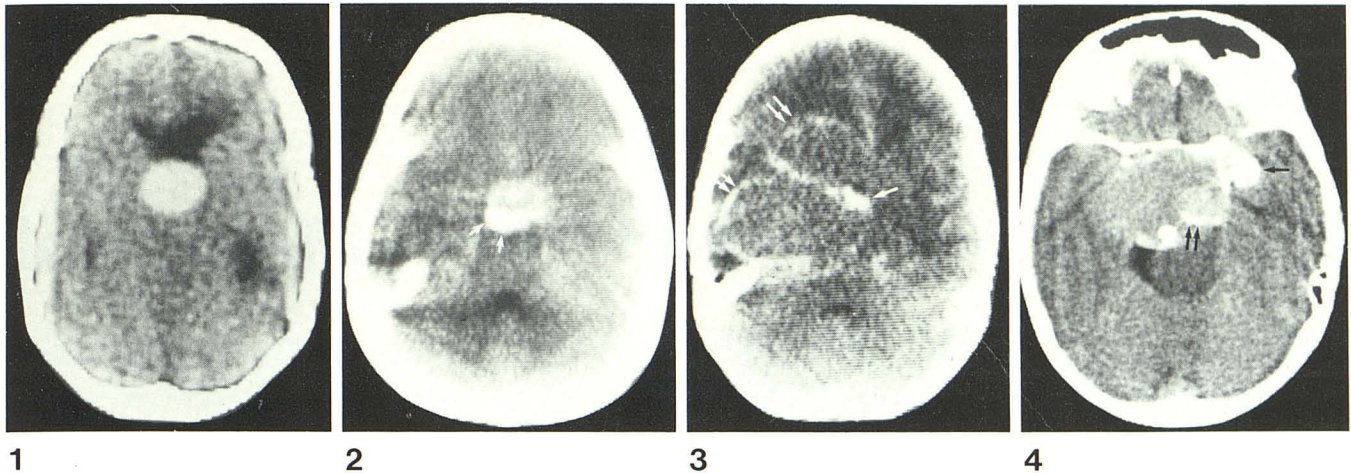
Case 1. Noncontrast CT scan. Midline, well circumscribed, sharply margined, hyperdense mass causing ventricular enlargement. After intravenous administration of contrast material, no significant enhancement was noted (not shown).
